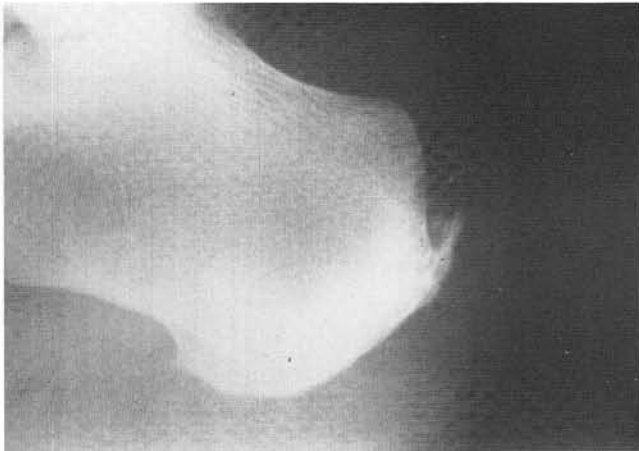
Preoperative X-ray of a posterior spur of the calcaneus.
